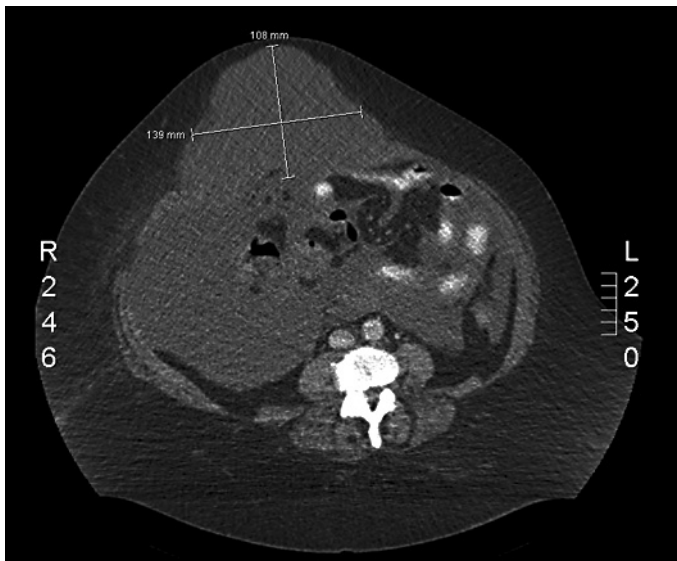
CT scan: Axial view demonstrating the distribution of ascites and the filling of the umbilical herniation measuring 139 × 108 mm.
